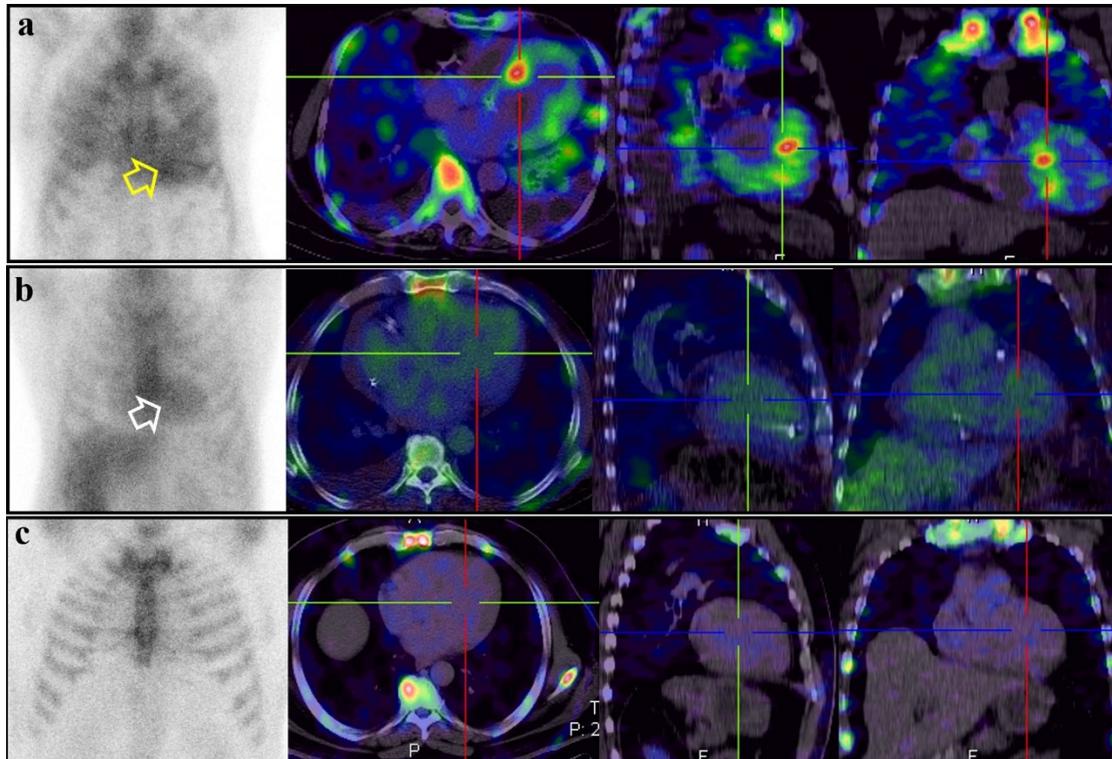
Myocardial radioactivity observed in three patients in [^{99m}Tc]Tc-PYP scans: (a) An 86-year-old male with positive ATTR-CA shows myocardial activity (yellow arrow) on planar imaging and SPECT/CT (PYP-90). (b) A 69-year-old male with negative ATTR-CA demonstrates activity localized to the blood pool (white arrow) (PYP-30). (c) A 45-year-old male shows no myocardial or blood pool activity on planar imaging and SPECT/CT (PYP-90)
